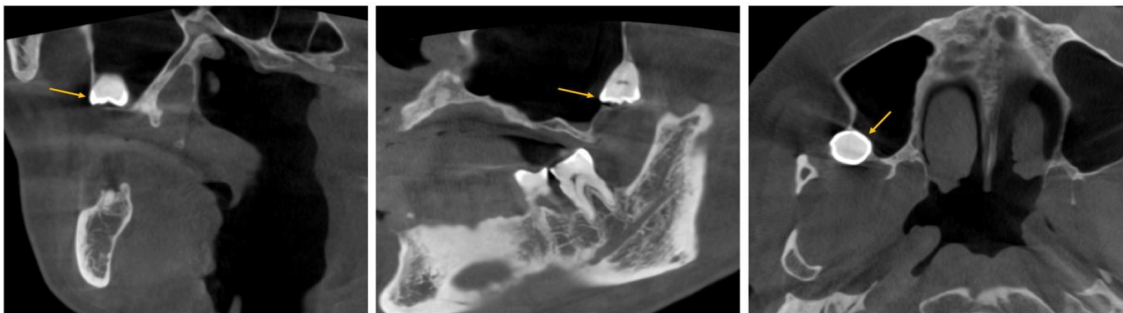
Coronal, Sagittal and Axial Sections of the CBCT scan revealing the presence of ectopic tooth in the left maxillary sinus
